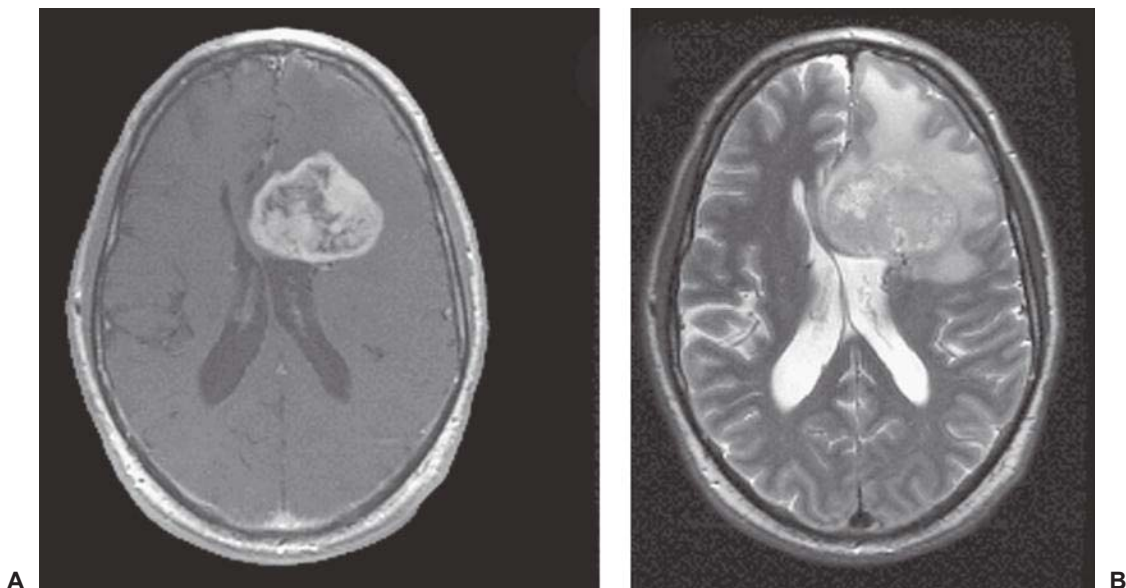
Magnetic resonance imaging of a patient with a malignant glioma demonstrates a large mass with heterogenous enhancement (A) and significant edema (B) on the T2-weighted sequences.
